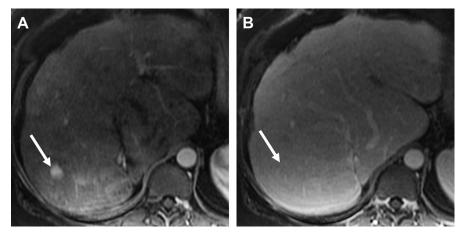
A 60-year-old man with history of Budd–Chiari syndrome secondary to polycythemia vera. Axial T1 FS arterial phase MR image obtained during hepatic arterial phase (*A*) shows an avidly enhancing lesion in segment 7 (*arrow*). The lesion became isointense to the liver parenchyma on portal venous phase (*B*). The lesion remained stable for 3 years consistent with benignity.
